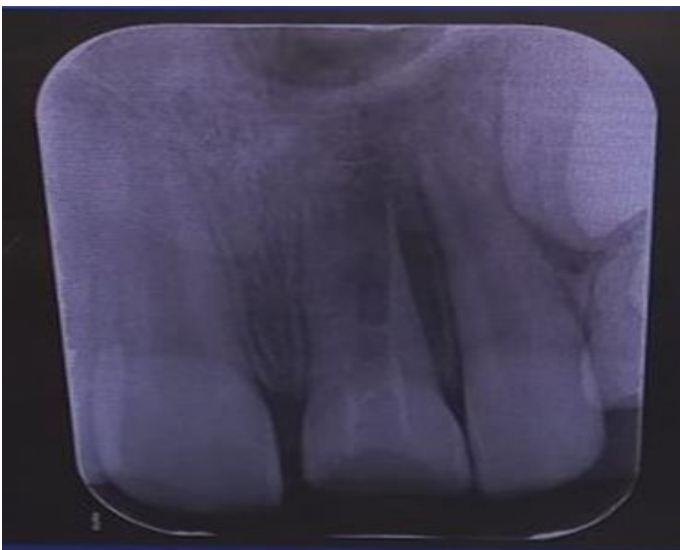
Radiographic image taken after calcination in the 2nd session
